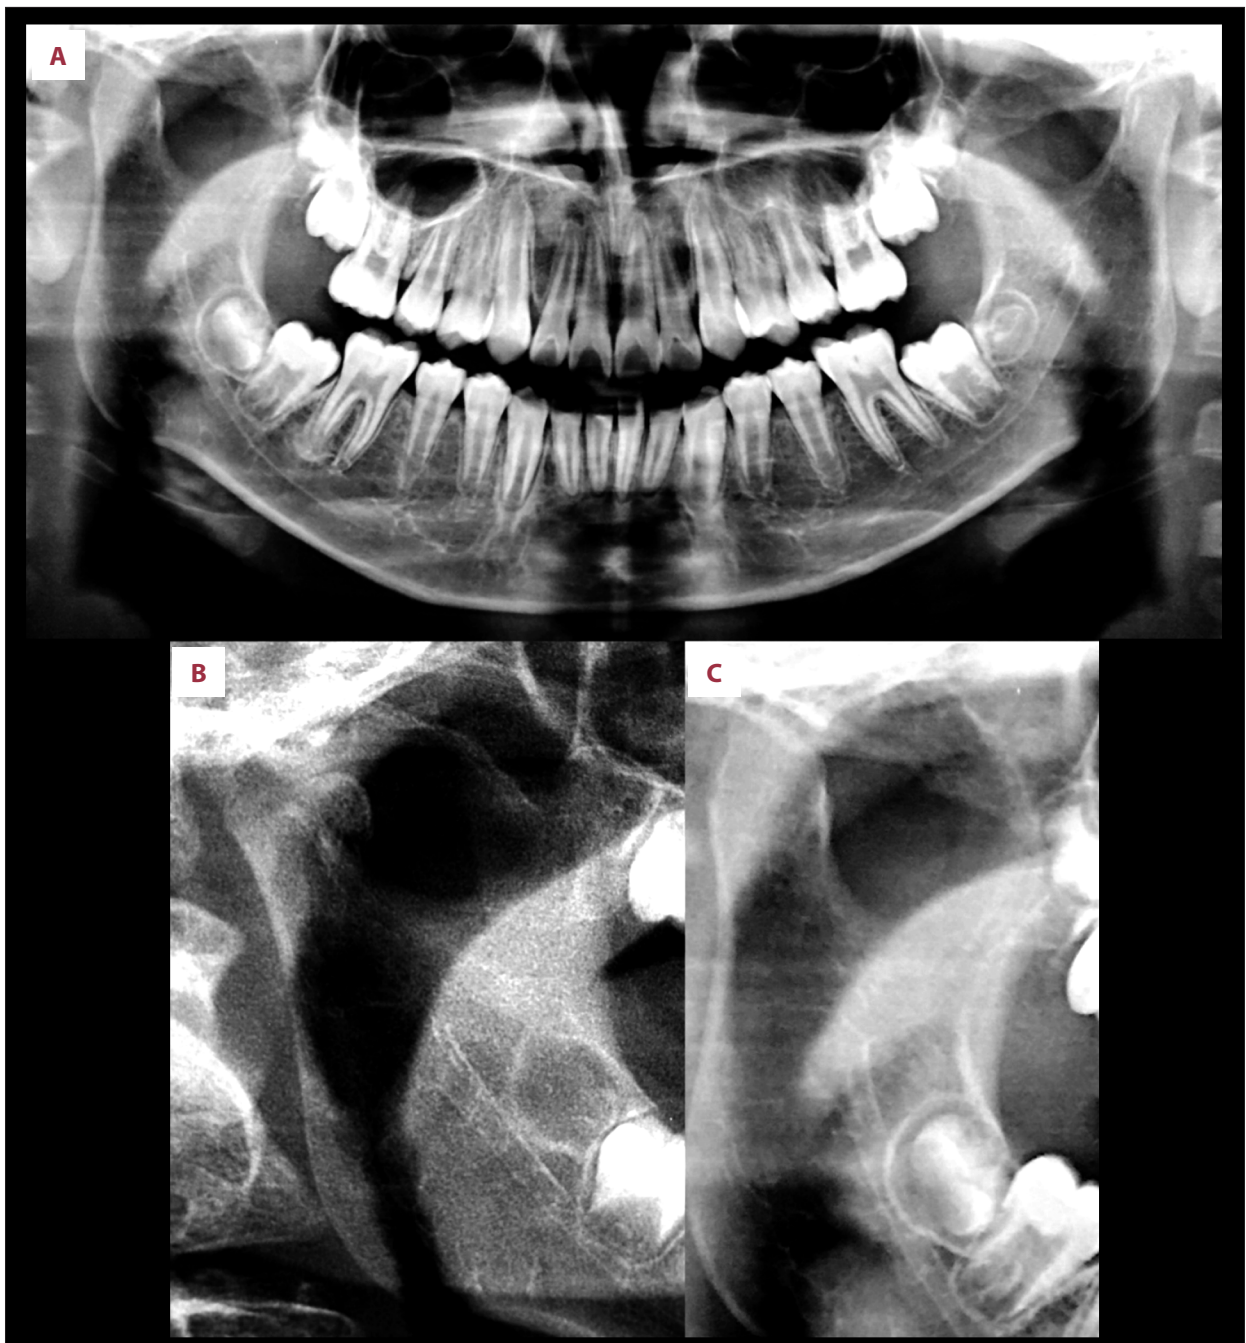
(A) Post-treatment orthopantomography showing recovery of the right high condylar fracture. (B) Pre-treatment condyle. (C) Post-treatment condyle.
